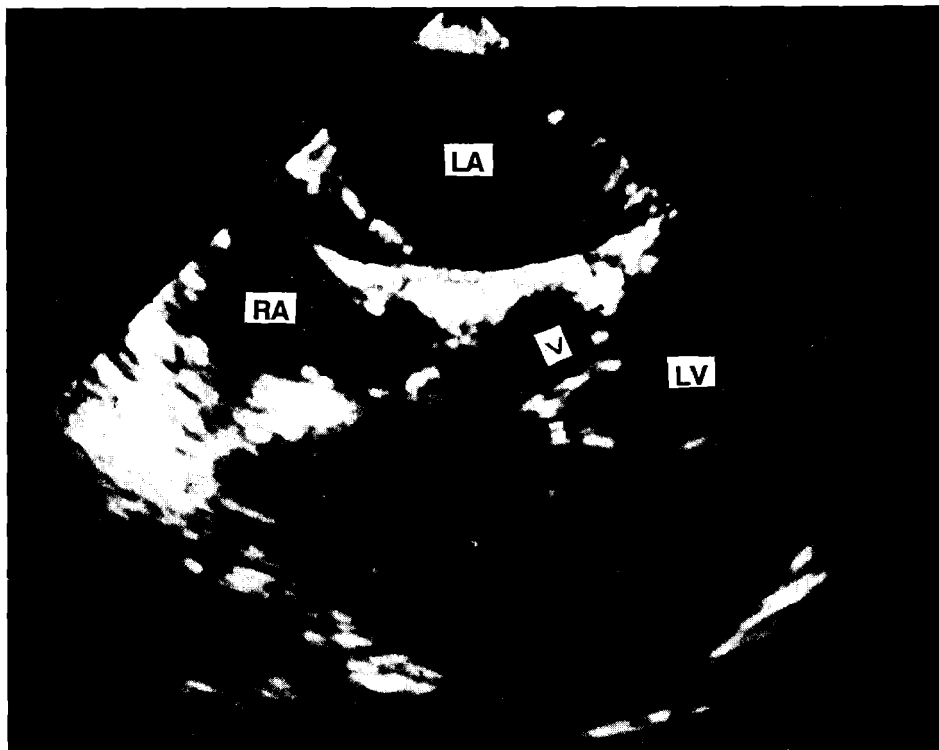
Transoesophageal demonstration of an additional papillary muscle (arrow) of the mitral valve in a 9.5 kg child producing left ventricular outflow obstruction. The prior praecordial study suggested a "membrane-like" lesion and documented abnormal diastolic movement of the anterior leaflet of the mitral valve; however the underlying pathology of the subvalvar apparatus was missed. Note the widely patent foramen ovale.
